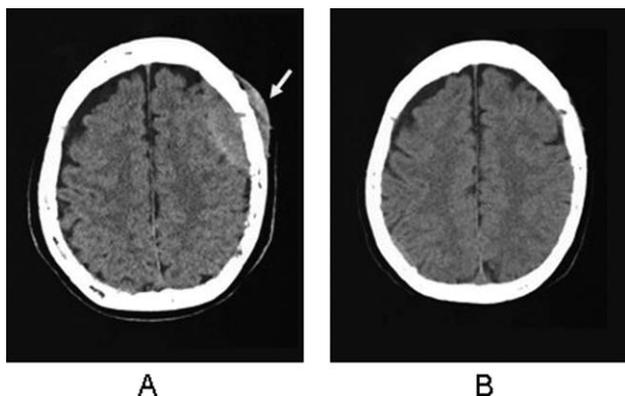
CT scan before (A) and on day 20 of the first course of lenalidomide plus low-dose dexamethasone (Rd) therapy (B). Arrow indicates plasmacytoma at the parietal bone. Plasmacytoma disappeared completely during the first course of Rd therapy.
